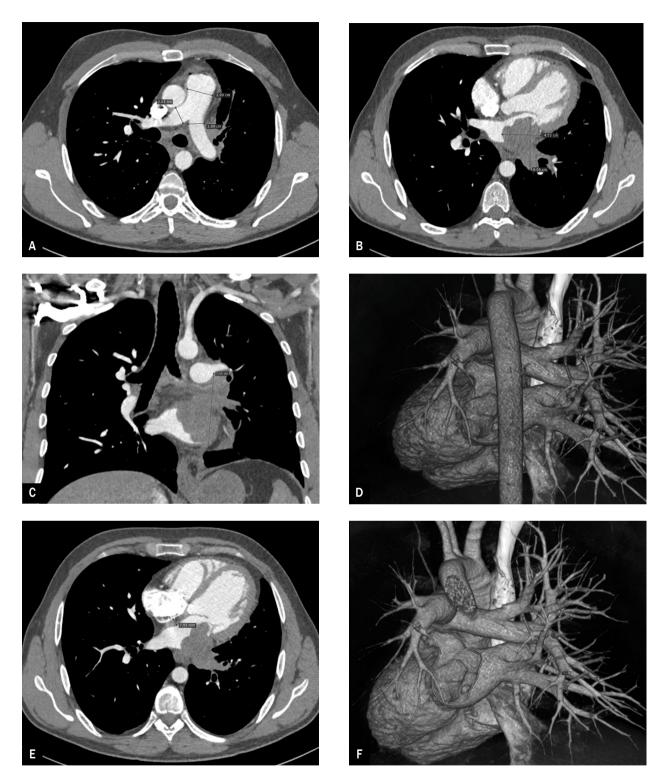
Left atrial tumor in computed tomography angiography images of pulmonary arteries: A. Axial reconstruction. Contrasted, nonexpanded main pulmonary arteries; B. Axial reconstruction. The tumor in the left atrium with transverse dimensions of approx. 6.0 × 4.5 cm; C. Frontal multiplanar reformation (MPR) reconstruction. A tumor in the left atrium with a cranial-caudal dimension of about 7.5 cm; D. Volume rendering technique (VRT) reconstruction. There is no contrast enhancement in the main venous trunks of the left lung; E. Axial reconstruction. Irregular thickening of the atrial septum; F. VRT reconstruction with removal of the descending aorta. Loss of left atrial lumen contrast enhancement and left pulmonary veins due to tumor mass
